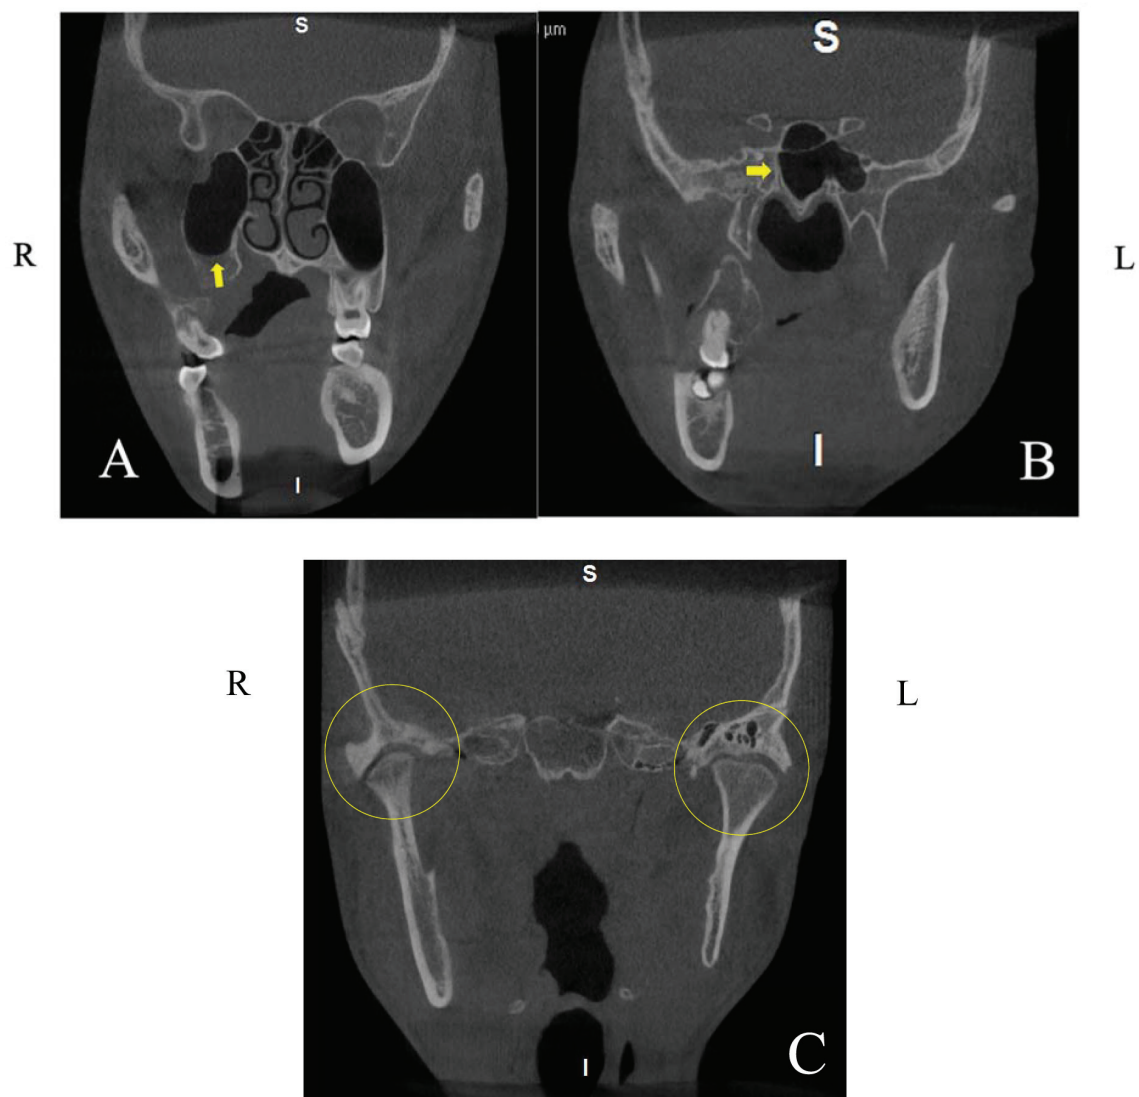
Coronal view of the patient's CBCT scan showing – A. displacement of the right maxillary sinus and nasal cavity; B. compression of the sphenoidal sinus to the left; C. position of condyles in relation to the glenoid fossa.
